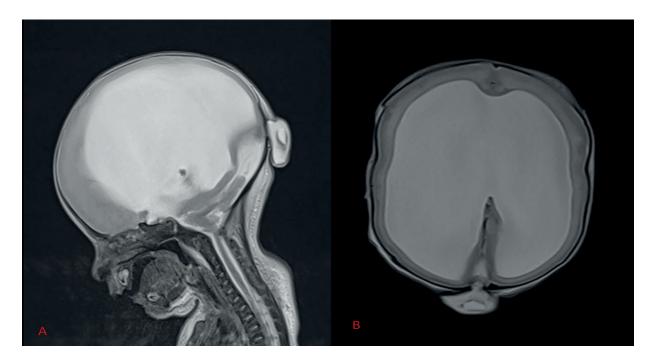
A, B, MRI sagittal and axial view of Hydrocephalus with occipital meningocele.
